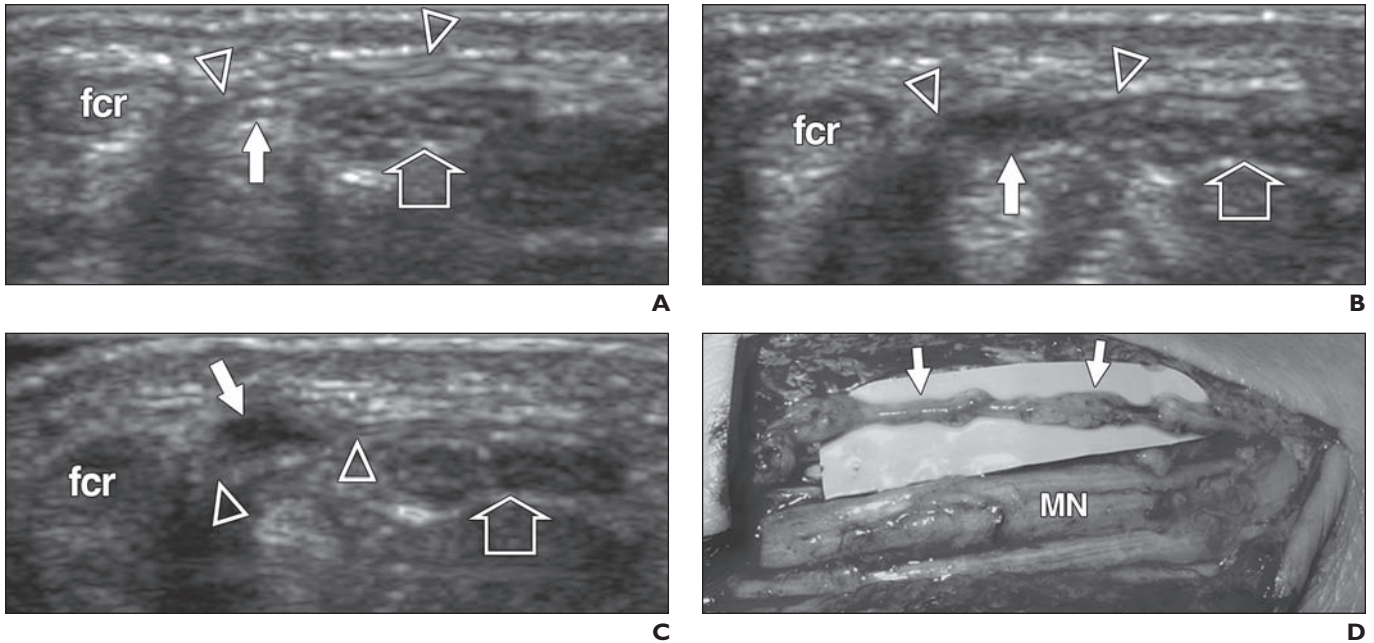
42-year-old woman with carpal tunnel syndrome and symptoms suggesting concurrent neuropathy of palmar cutaneous branch of median nerve (MN). Transverse 17.5-MHz sonography images were obtained from proximal to distal over palmar cutaneous branch of MN. A, Normal-appearing palmar cutaneous branch of MN (solid arrow) runs deep in relation to antebrachial fascia (arrowheads), passing between median nerve (MN) (open arrow) and flexor carpi radialis tendon (fcr). B and C, Palmar cutaneous branch of MN (solid arrow) exhibits focal fusiform hypoechoic swelling as it enters fascial tunnel (B) and after crossing it (C). Arrowheads = antebrachial fascia, fcr = flexor carpi radialis tendon, open arrow = median nerve. D, Gross surgical view after fascial release confirms presence of irregularly thickened palmar cutaneous branch of MN (arrows). MN = median nerve.
